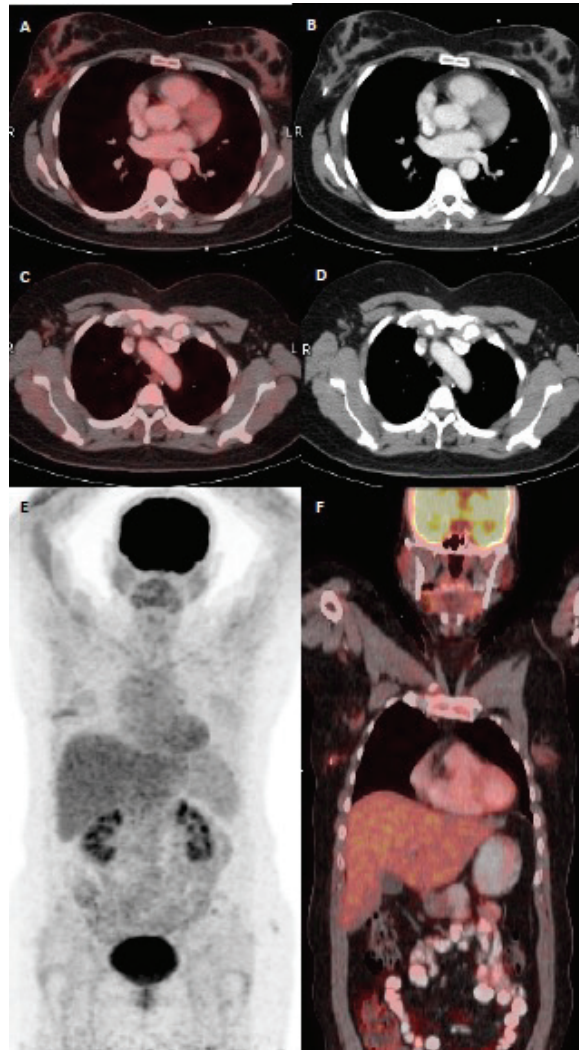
¹⁸F-FDG PET/CT was performed following appropriate chemotherapy, without any ¹⁸F-FDG uptake in the whole body 4 months after the initial PET/CT study. The axial PET/CT and CT images (A, B, C, D) of the control PET/CT scan show no pathological ¹⁸F-FDG uptake in the right breast and axilla. Whole-body MIP (E) and coronal PET/CT (F) images revealed complete regression of the disease.
